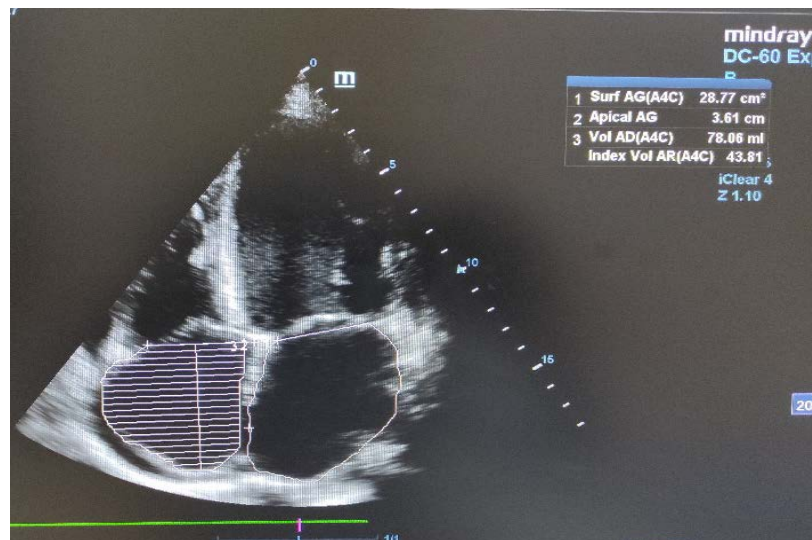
Transthoracic echocardiography in apical 4-cavity window showing bi-atrial dilatation in a patient with peripartum cardiomyopathy in Parakou in 2022.
